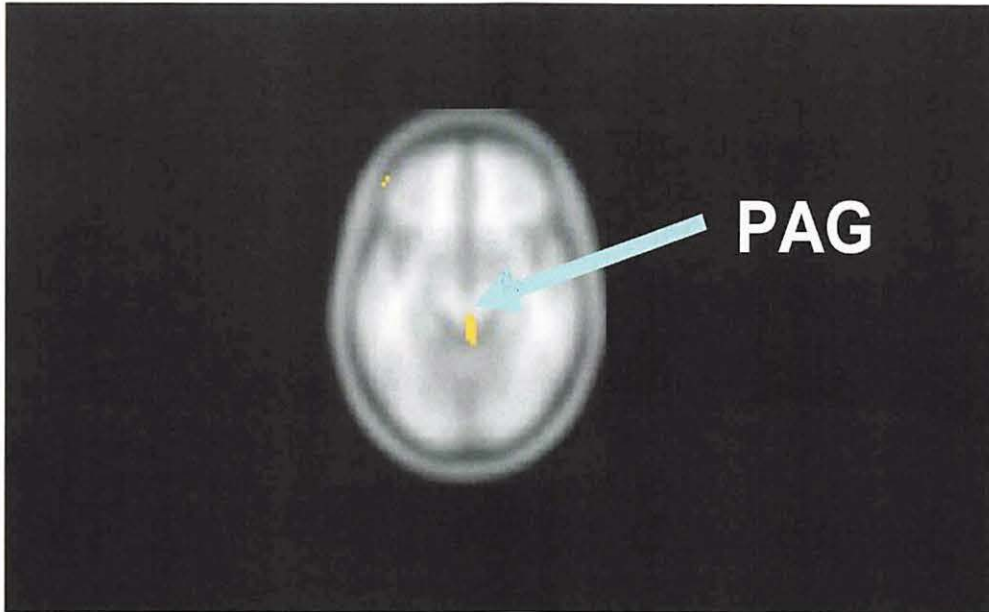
Areas of rCBF increase during the dual stimuli as compared to the intense itching stimulus (uncorrected p value < 0.005). Blue arrow shows PAG on a transaxial slice of the MRI template.
